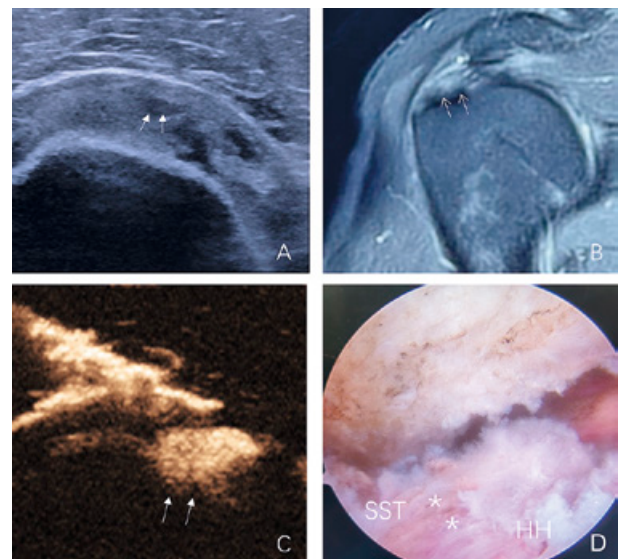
A 31-year-old male with intratendinous partial-thickness tear of supraspinatus: (A) US revealed an intratendinous hypoechoic area of supraspinatus tendon in the long-axis view (↑↑); (B) An oblique coronal MRI image revealed a brighter signal within the supraspinatus tendon (↑↑); (C) PUSB image revealed contrast agent filling in the tear area within the supraspinatus tendon (↑↑), which indicated an intratendinous partial-thickness tear in the long-axis view; (D) Arthroscopy confirmed that an intratendinous partial-thickness tear (↑↑) changed to a bursal-side partial-thickness tear during surgical exploration.
